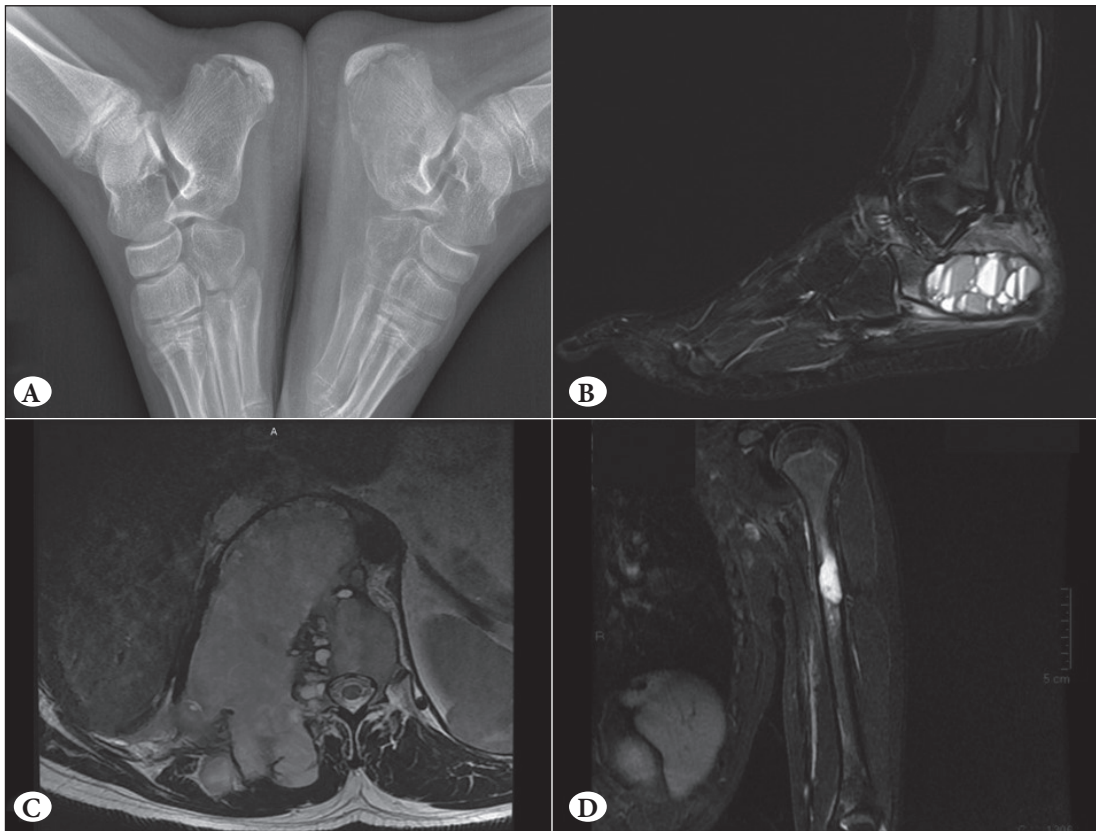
Examples of radiological images. A) Minimal expansive lytic lesion in calcaneus, left foot, plain radiography, B) Fluid-fluid level in a cystic lesion, consistent with aneurysmal bone cyst, in calcaneus, magnetic resonance imaging (MRI), STIR sequence, sagittal view, C) Hyperintense cystic lesion consistent with simple bone cyst located in diaphysis of humerus, MRI, STIR sequence, coronal view, D) Paravertebral hydatid cyst at T11-L1 level. Destruction and compression is remarkable on T12 corpus. MRI, T2 weighted axial view.
